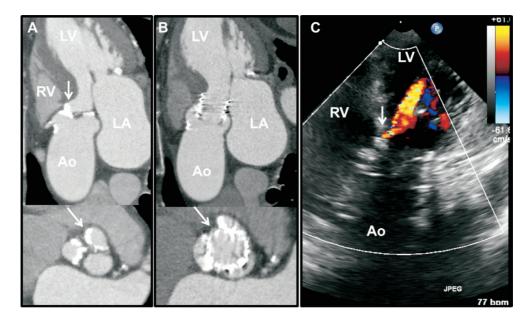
Panel A shows a calcified tricuspid aortic valve of a patient with bulky calcification mainly in the non-coronary (arrow) and right cusps, and extending to the base of the interventricular septum (arrow) on multidetector computed tomography (MDCT). Following TAVI with a balloon-expandable (SAPIEN XT) valve, a paravalvular leak was observed with colour-coded Doppler transoesophageal echocardiography (TEE) that coincided with the location of the bulky calcification at the commissure between the right and non-coronary cusps on MDCT. Panel B shows the deployed frame and the arrow indicates the gap at the level of the commissure between the non-coronary and right cusps. Panel C shows the colour-coded Doppler TEE in a transgastric view with the paravalvular leak in the location of the calcification at right to non-coronary commissure.
